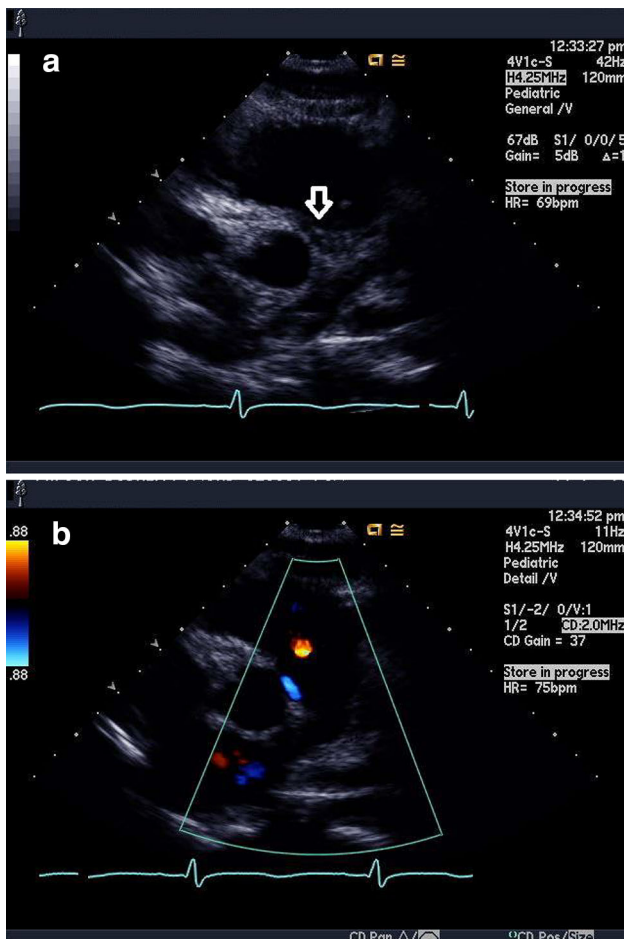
Superior parasternal short axis (in same patient as Fig. 1) demonstrating anomalous left coronary in same patient in a 2D (arrow) and b color Doppler (blue)
